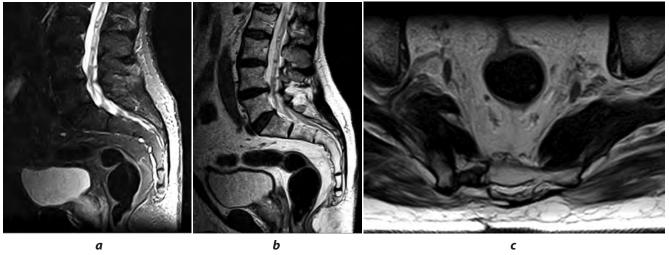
Patient R., MRI of the lumbosacral spine in 2 projections with contrast enhancement, before the surgery. Giant presacral tumor of retroperitoneal localization at the S3 level on the right, with intraforaminal component. a, b – sagittal sections; c – axial section; d – scheme of topographic and anatomical features of the tumor localization.
